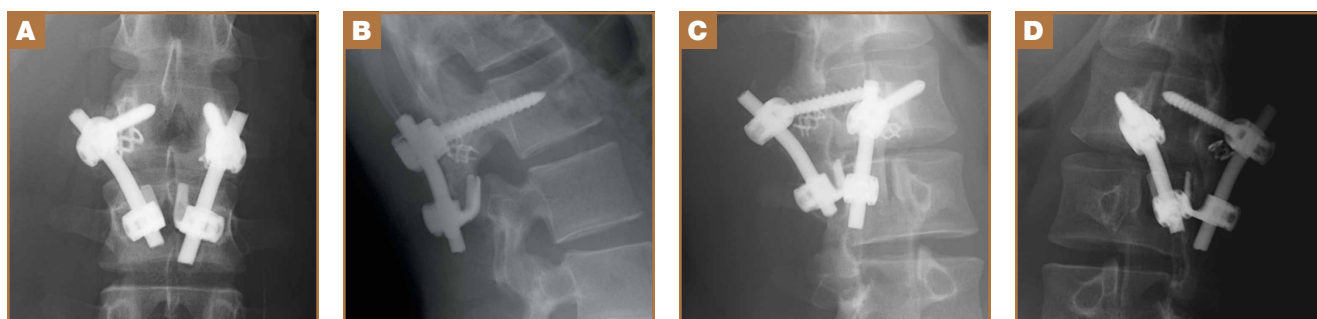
One-year follow-up (A) posteroanterior, (B) lateral, and (C, D) bilateral oblique radiographs of the lumbar spine show bilateral pedicle screws, bone cages, vertical rods, and laminar hooks providing fixation of the bilateral pars interarticularis defects without recurrence of osteoid osteoma. Solid bone healing of the pars defects is also evident.
